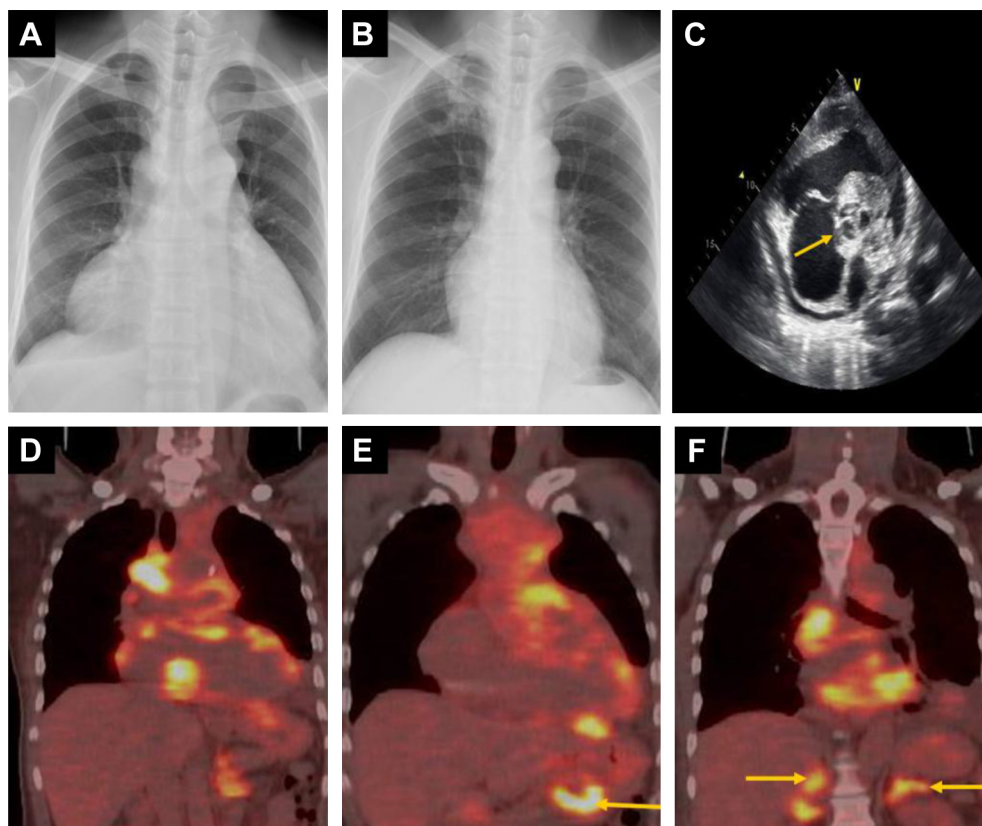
(A) Initial chest X-ray at the time of diagnosis shows a mediastinal mass with water bottle heart sign. (B) Chest X-ray after treatment reveals normal heart size and disappearance of the mediastinal mass. (C) Cardiac echo shows pericardial effusion and a suspected tumor encasing the aorta (arrow). (D–F) Positron emission tomography scan shows lesions over multiple mediastinal lymph nodes, cardiac wall, stomach (E, arrow), and bilateral adrenal glands (F, arrows).
